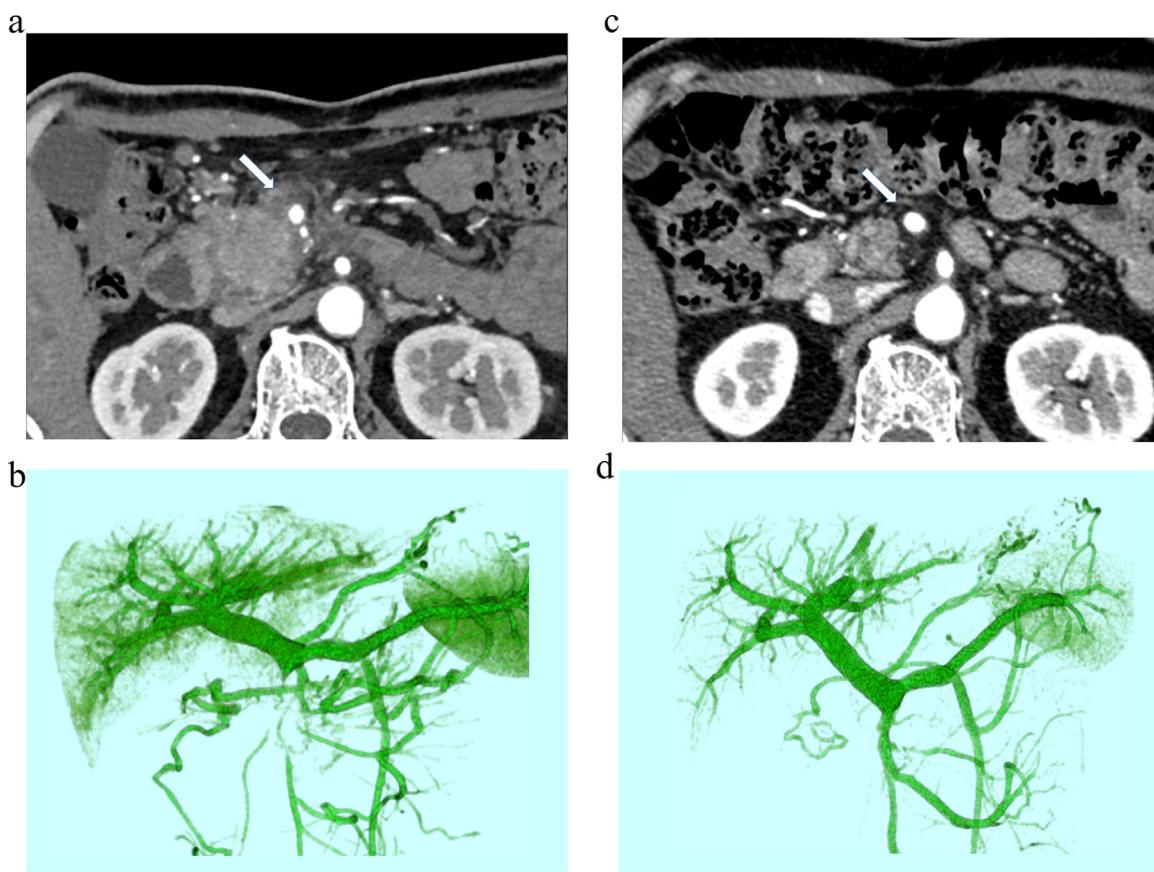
Contrast-enhanced computed tomography images: a. A tumor of approximately 4.0 cm in the pancreatic head with invasion extending into the plexus nerve around the superior mesenteric artery (SMA) before chemotherapy (arrow); b. The tumor occluded the superior mesenteric vein (SMV) completely. The tumor was diagnosed as an unresectable locally advanced pancreatic head cancer; c. After chemotherapy, the tumor shrank substantially, and the invasion into the plexus nerve around the SMA became unclear (arrow); d. The SMV became patent. The tumor was diagnosed as a borderline resectable pancreatic cancer.
